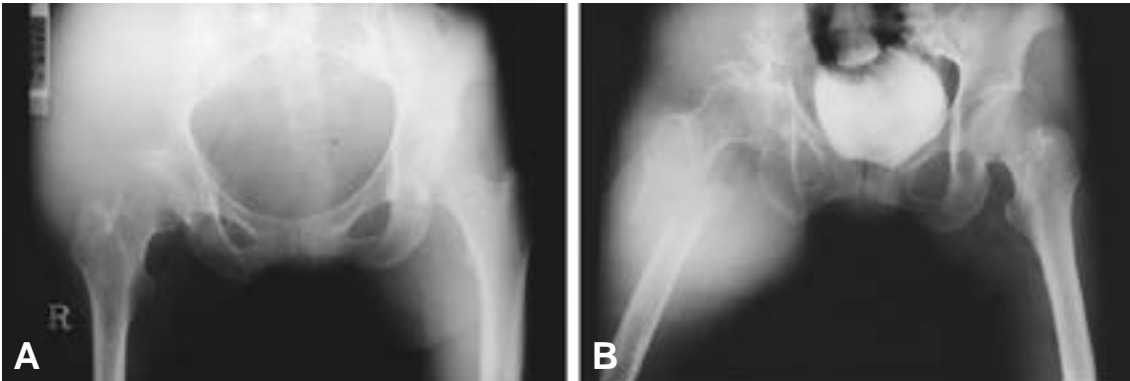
A : Initial roentgenogram shows osteolytic lesion on the right ilium and huge soft mass on the right buttock. .
